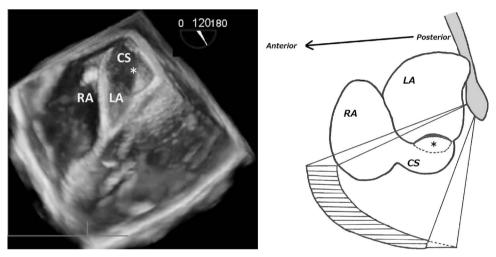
Real-time three-dimensional echocardiography shows overview of unroofed portion from left atrium side. Right supplemental fugure give an explanation the positional relationship between transesophageal echocardiography probe and unroofed coronary sinus with a sagital view. LA = left atrium; CS = coronary sinus; RA = right atrium
